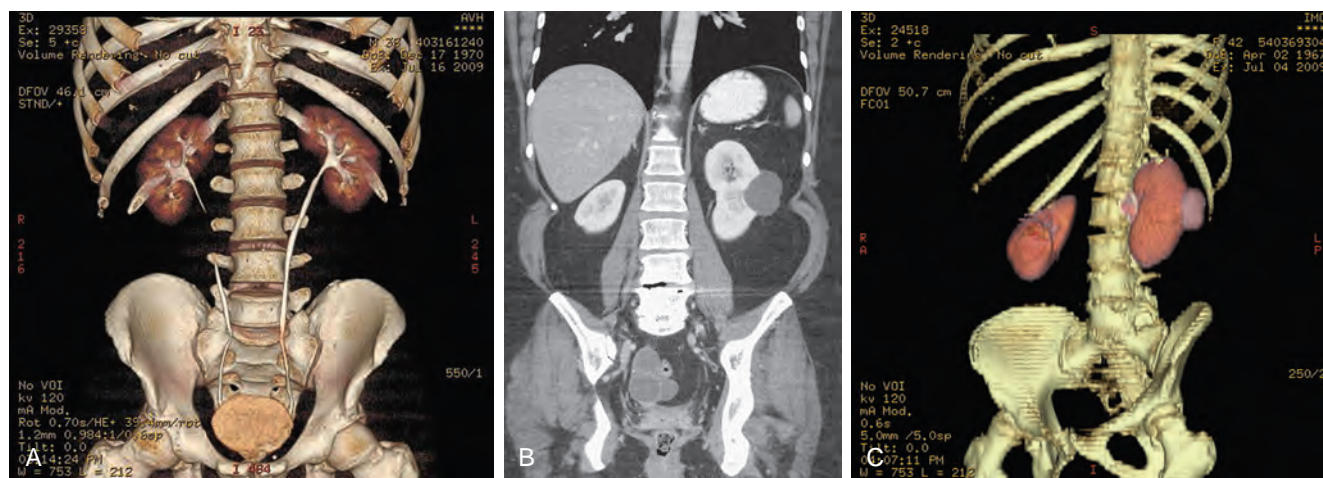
A, Three-dimensional (3D) colored reconstruction of the kidneys, ureters, and bladder from computed tomography urogram. B, Coronal reconstruction in a patient with a clear cell renal cell carcinoma in a complex renal cystic mass and enhancing mural nodule. C, 3D reconstruction of the same patient with slight posterior rotation.
